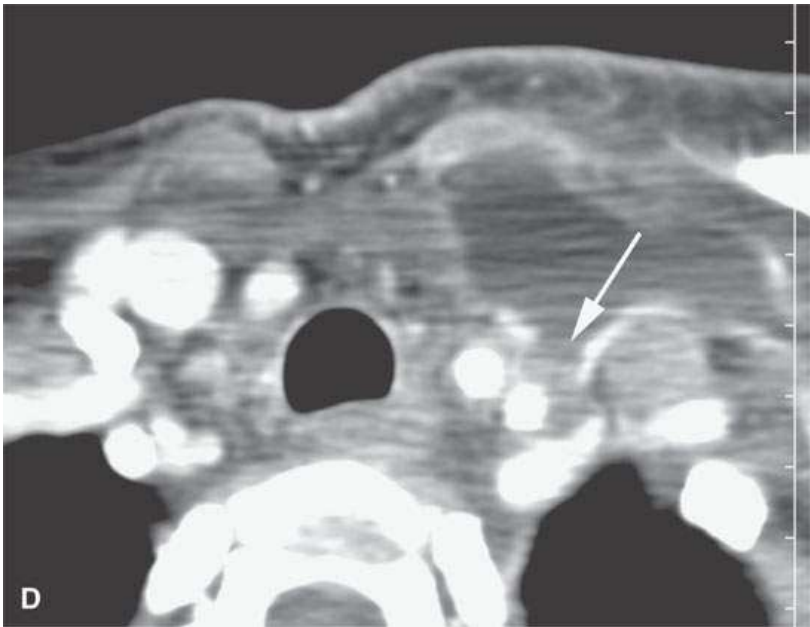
Contrast-enhanced computed tomography showing a postoperative seroma and chyle leak. Some areas of the fluid collection show reactive enhancement along its margins (*arrow* in A) while others do not (*arrowhead* in A). A, B: The collection lies deep to the closure of the superficial fascia (*arrows*) and around the carotid sheath and in the posterior triangle. C, D: The collection is mainly deep to the investing layer of cervical fascia and then projects into the region where the thoracic duct joins the subclavian vein (*arrow*) suggestive of a chyle leak, explaining at least part of the fluid collection.
